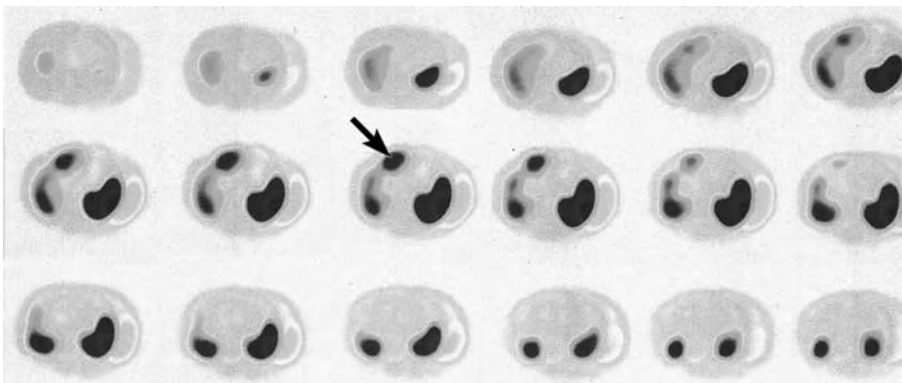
^{111}In -DOTA-lanreotide scintigraphy in a patient with colon cancer and a single liver metastasis (arrow) at 3 h post injection of 150 MBq radioligand. SPECT: transverse reconstruction
